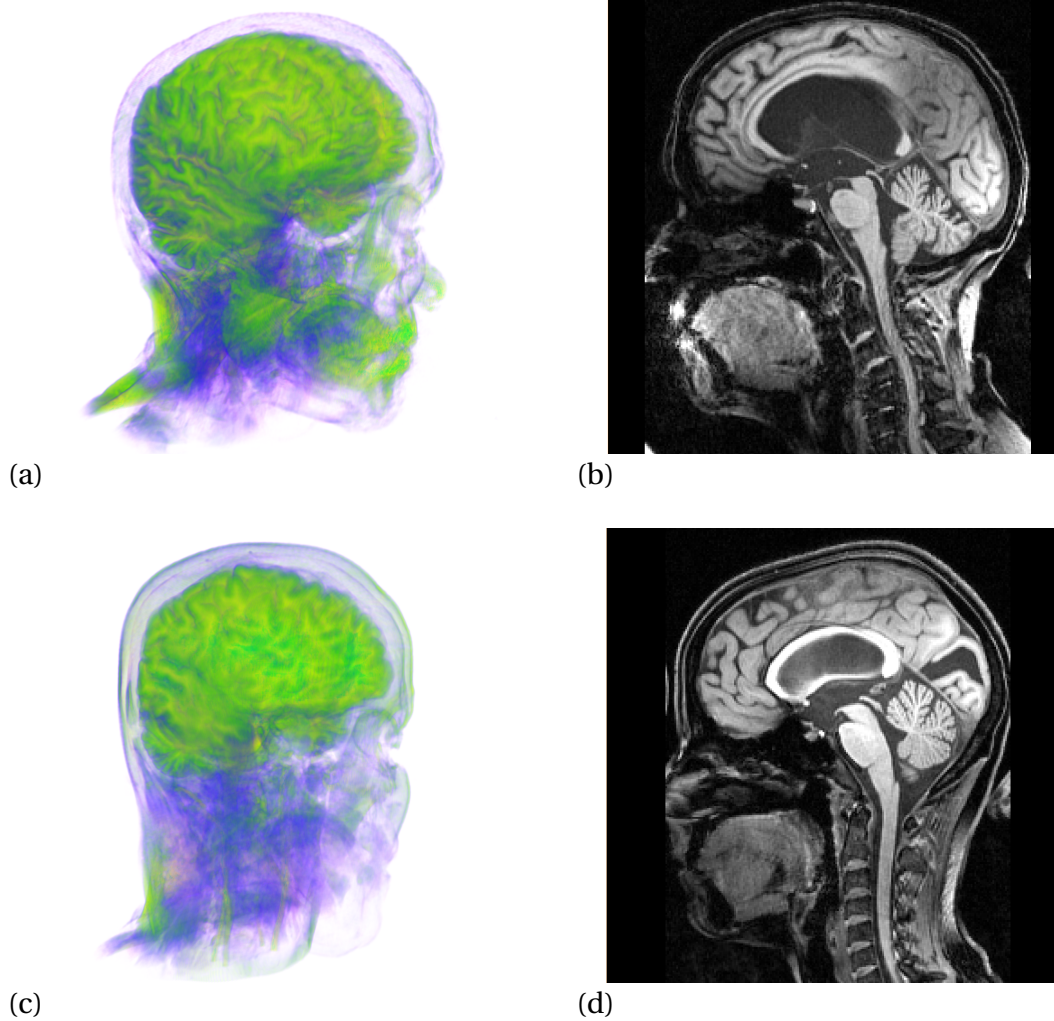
Patient-specific MRI scans: (a), (b) Case 4, a late-sixties male patient with no abnormal physical signs apart from a history of gait disturbance; and, (c), (d) Case 5, a patient presenting with acute chronic headache, blurred vision, dizziness and nausea, and speech difficulty but no gait disturbance or urinary incontinence.
